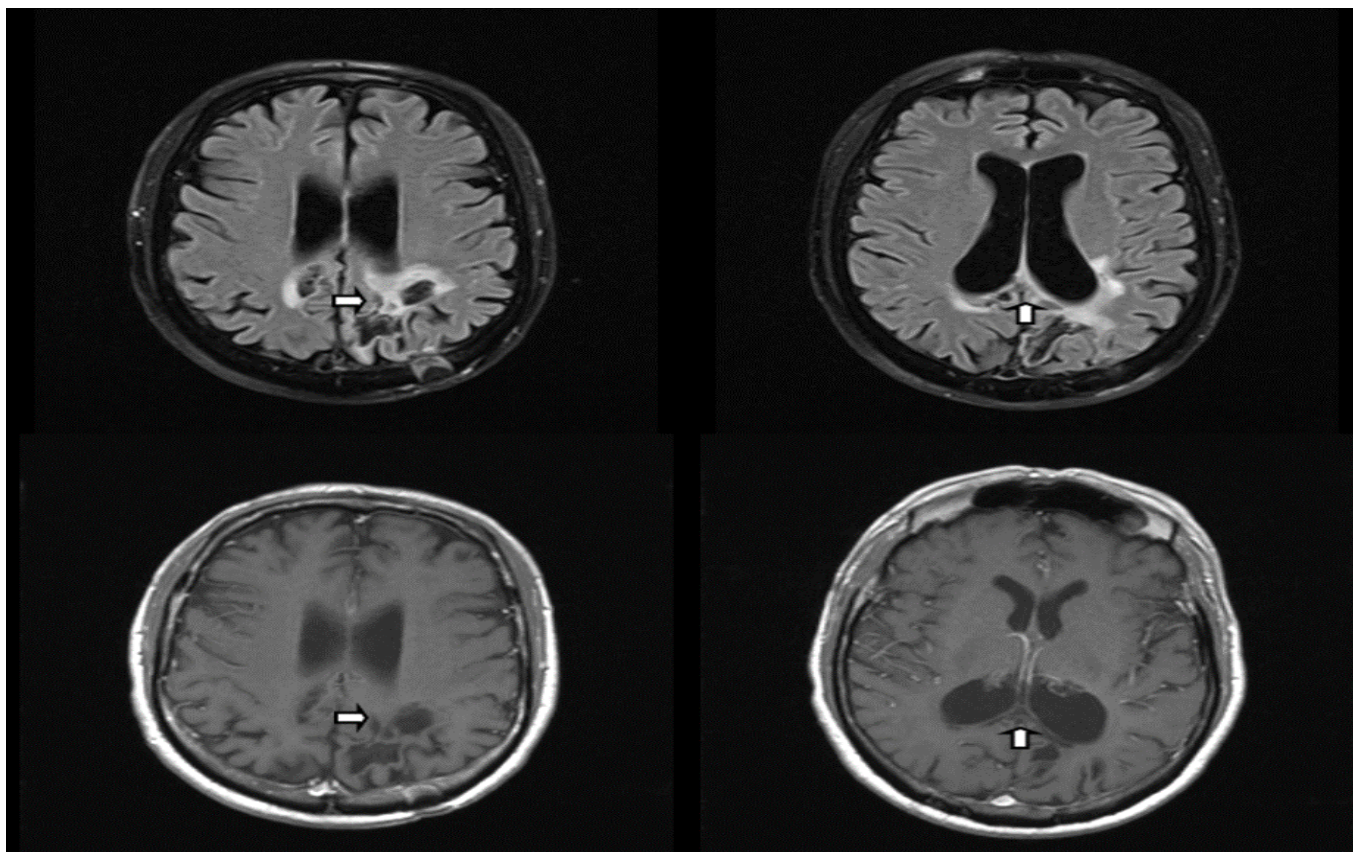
Pre and post contrast brain MRI following chemotherapy. FLAIR-weighted sequence (top images) demonstrates decreased volume of the lesion (arrow). T1-weighted pre and post-contrast sequence (bottom images) demonstrate resolution of the previously seen enhancement (bottom images arrows).
